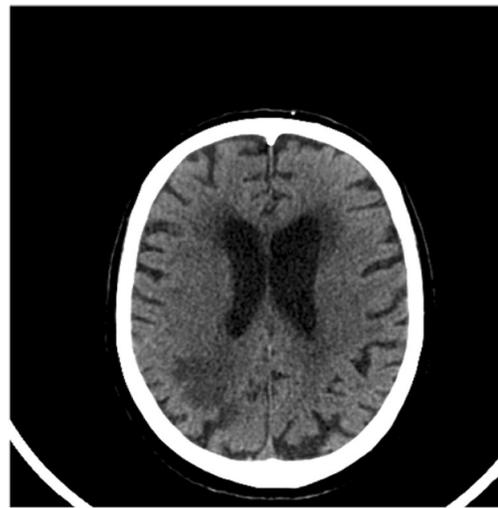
Recent right parietal infarction on CT scan
